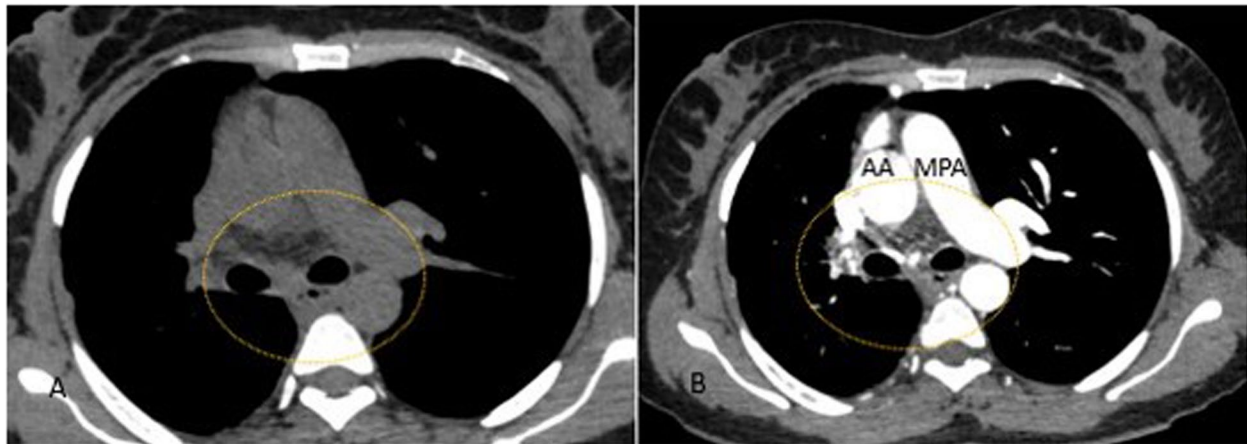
CT thorax mediastinal window (A- plain study, B- CT Angiography) shows presence of the Main pulmonary trunk and left pulmonary artery and absence of right pulmonary artery. [AA- Ascending aorta, MPA- Main Pulmonary artery]
